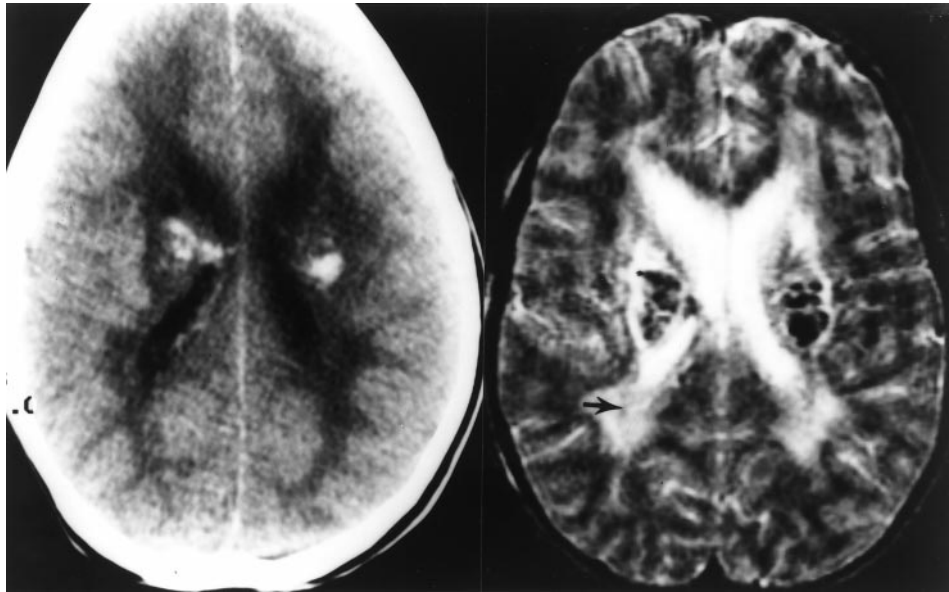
Axial computed tomography image of the brain demonstrates increased bilateral attenuation in the basal ganglia and corona radiata. An axial T₂-weighted magnetic resonance image (TR = 3,000 ms, TE = 120 ms) 5 days later reveals putamenal hemorrhage, with cystic changes bilaterally, and hyperintense signal in the white matter (arrow).
